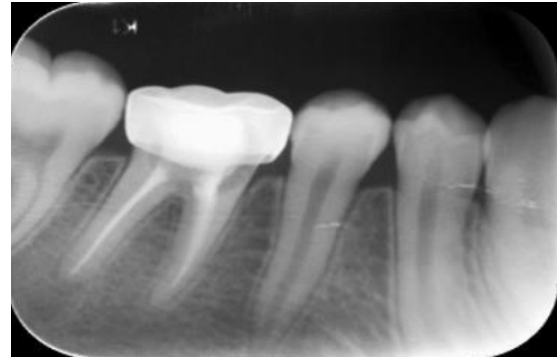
IOPAwrt 46 with absence of furcal and periapical radiolucency
